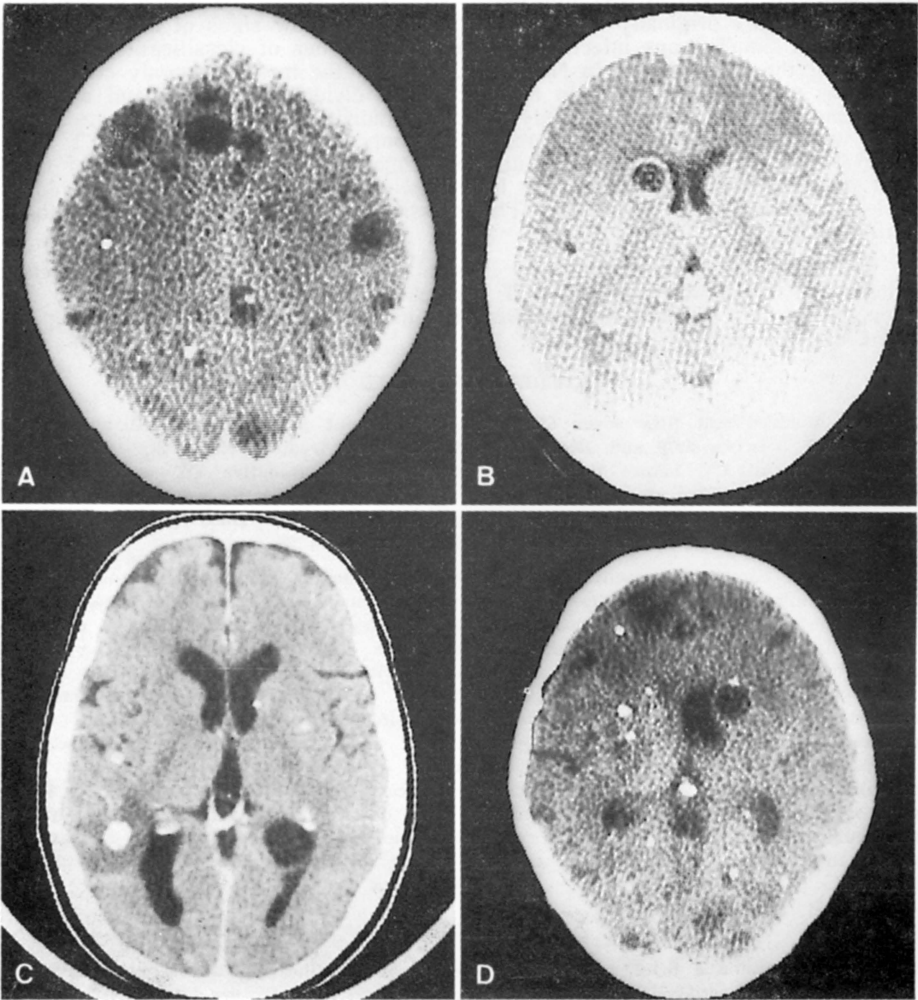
CT findings in neurocysticercosis. A. Typical neurocysticercosis CT with some evolutive phases: sharp vesicles; unsharp vesicles; vesicles with nodular scolex calcifications; some nodular calcifications. B. Detail of an annular enhancement: cysticercus with surrounding inflammatory signs, suggesting a degenerative phase. C. Detail of a nodular enhancement: vesicle with inner contrast capture; there is also a vesicle near the ventricular system, and some calcifications are present. D. Nodular calcifications; some vesicles and a nodular scolex calcification are seen also.
